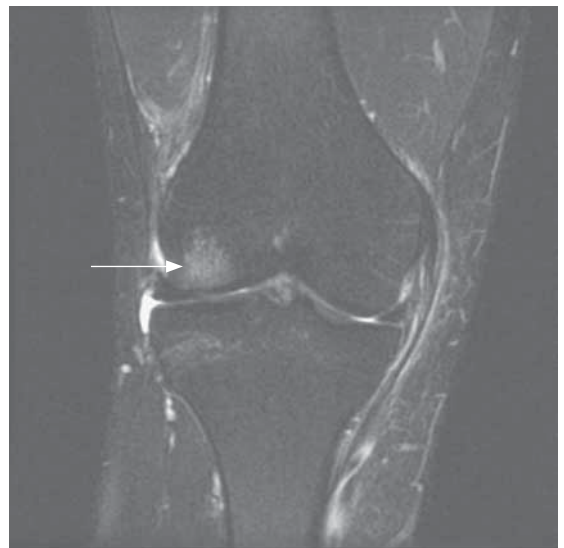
MRI showing a bone bruise of the lateral femoral condyle in association with an ACL tear
